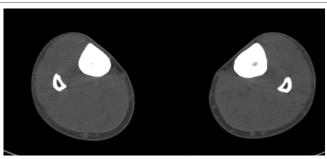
Sagittal CT, tibial diaphyseal medullary fully closed.
